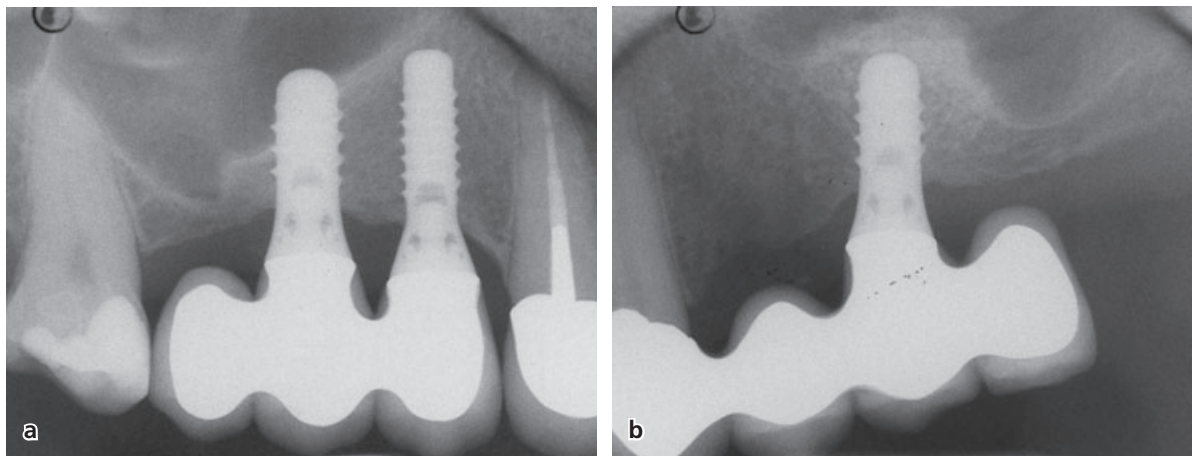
(a) A radiograph, taken at the 5-year follow-up visit, of an implant placed in the 1st quadrant utilizing the osteotome technique without grafting material. A new cortical bony plate at the inferior border of the maxillary sinus is clearly visible, but no bony structure can be detected apical to the implant. (b) A radiograph (same patient) of an implant placed in the 2nd quadrant utilizing the osteotome technique with xenograft grafting material, taken after 5 years in function. A dome-shaped structure is clearly visible documenting a definite increase in bone volume compared to the initial situation. The “dome” is surrounded with a new cortical bony plate.
